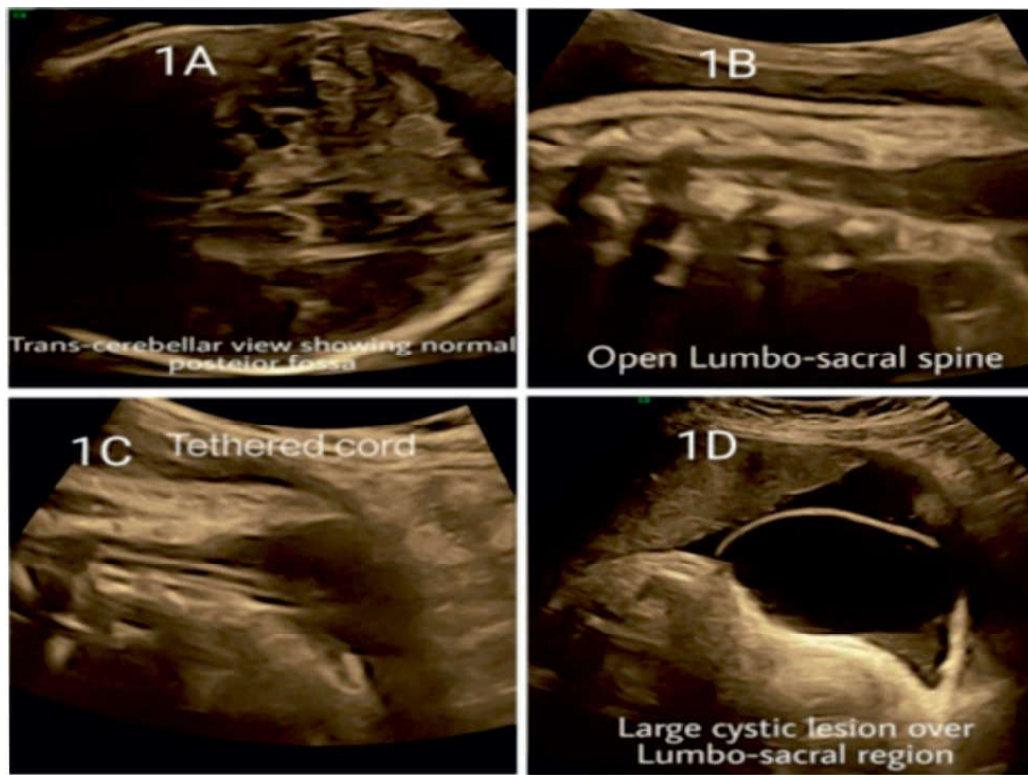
ultrasound finding at 36 weeks.
